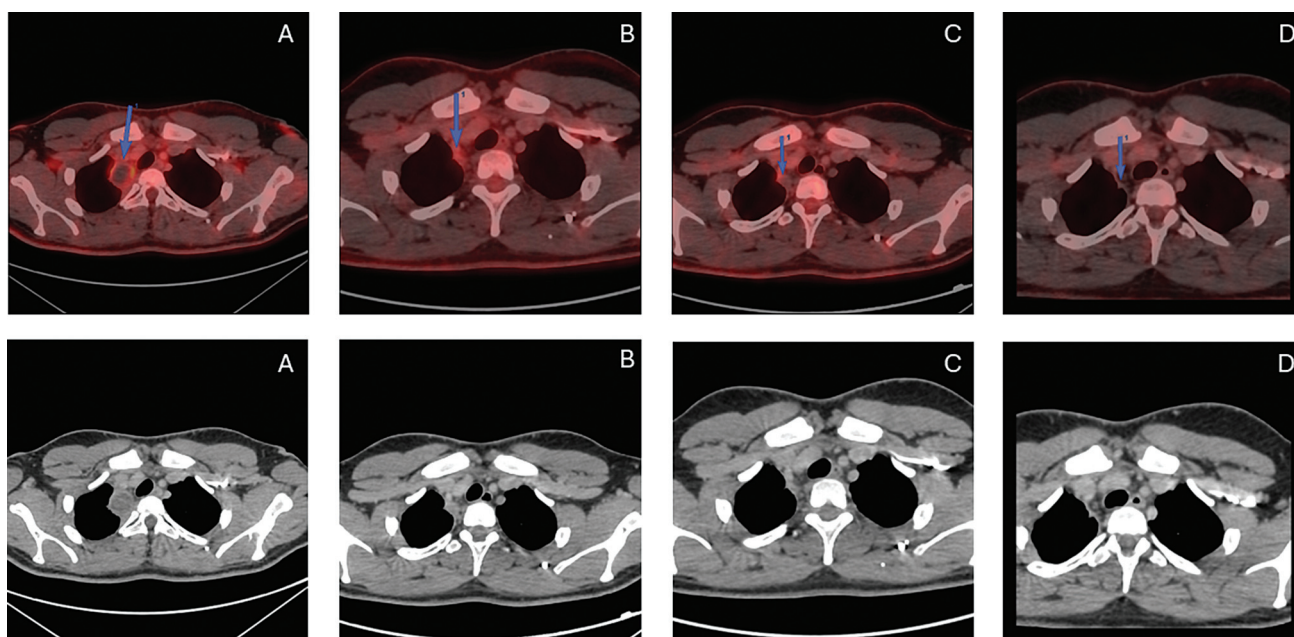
Sequential fluorodeoxyglucose (FDG) positron-emission tomography-computed tomography (PET-CT) images tracking treatment progress. (A) August 2021, enlarged lymph node in the right upper tracheal region. (B) January 2022, reduction in node size and radiopharmaceutical uptake. (C) August 2022, continued decrease in node size. (D) November 2022, complete metabolic response with no signs of active malignancy.
